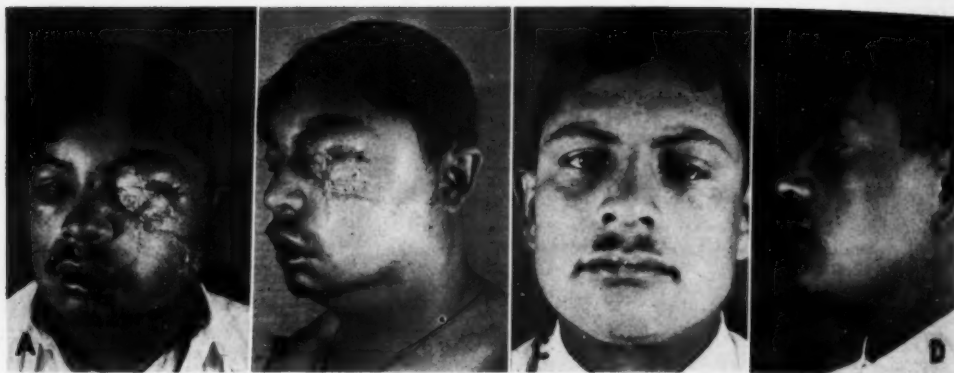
Case I. A and B. Before roentgen treatment. C and D. Following treatment.
